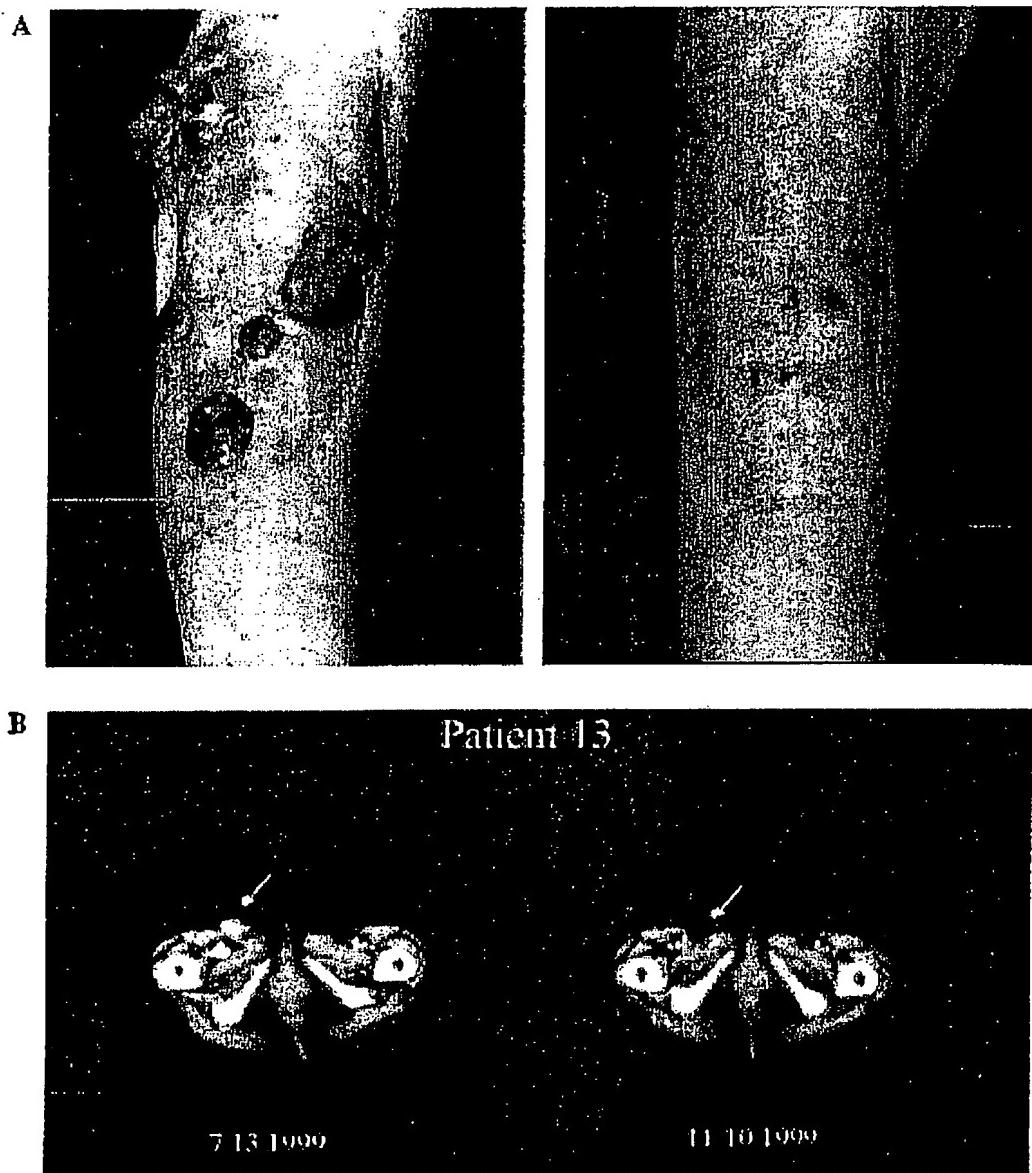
Response following 4 weeks of treatment with oblimersen in a 90-year-old woman with malignant melanoma and bulky metastases to pelvic lymph nodes and at the site of a previous skin graft. (A) Skin metastases. (B) Computed tomography of pelvis. Reprinted with permission from Elsevier Science in Jansen, B., Wachek, V., Heere-Ress, E., Schlagbauer-Wadl, H., Hoeller, C., Lucas, T., Hoermann, M., Hollenstein, U., Wolff, K., and Pichamberger, H. (2000). Chemosensitization of malignant melanoma by bcl2 antisense therapy. *Lancet* 356, 1728–1733.
